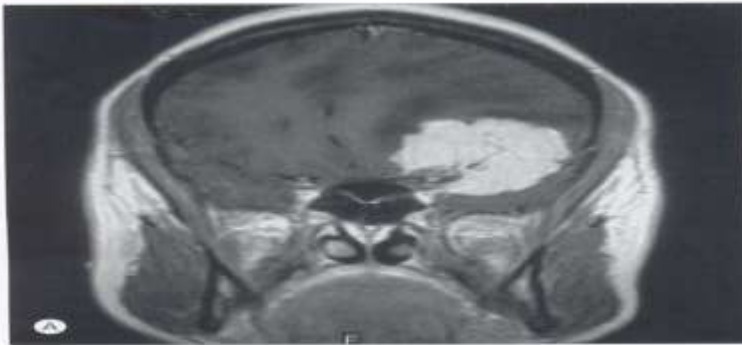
Coronal (A) and sagittal (B) MR images of a medial sphenoid ridge.
